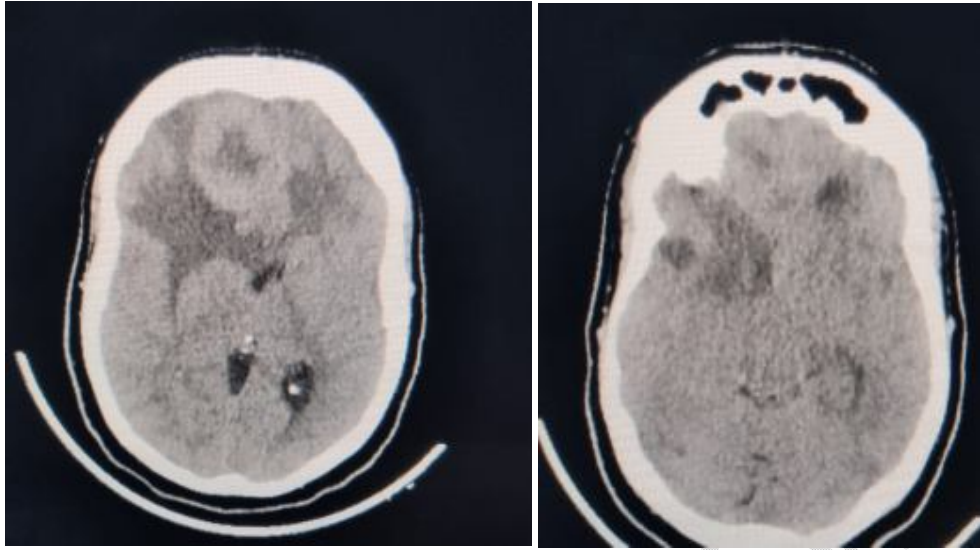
Post-operative CT brain.
